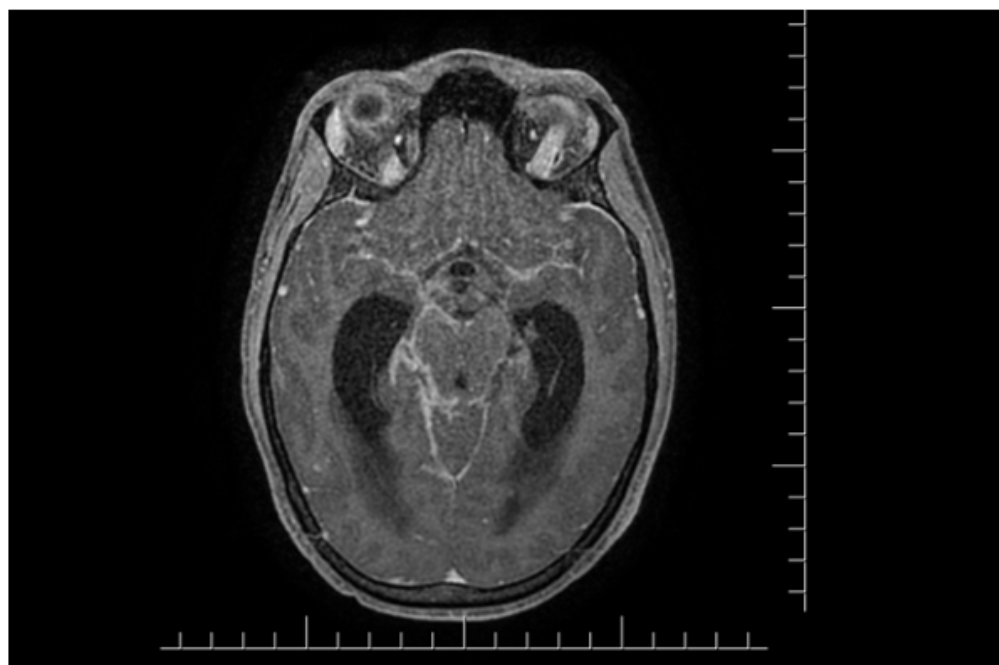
MRI Brain, narrowing both MCAs.
